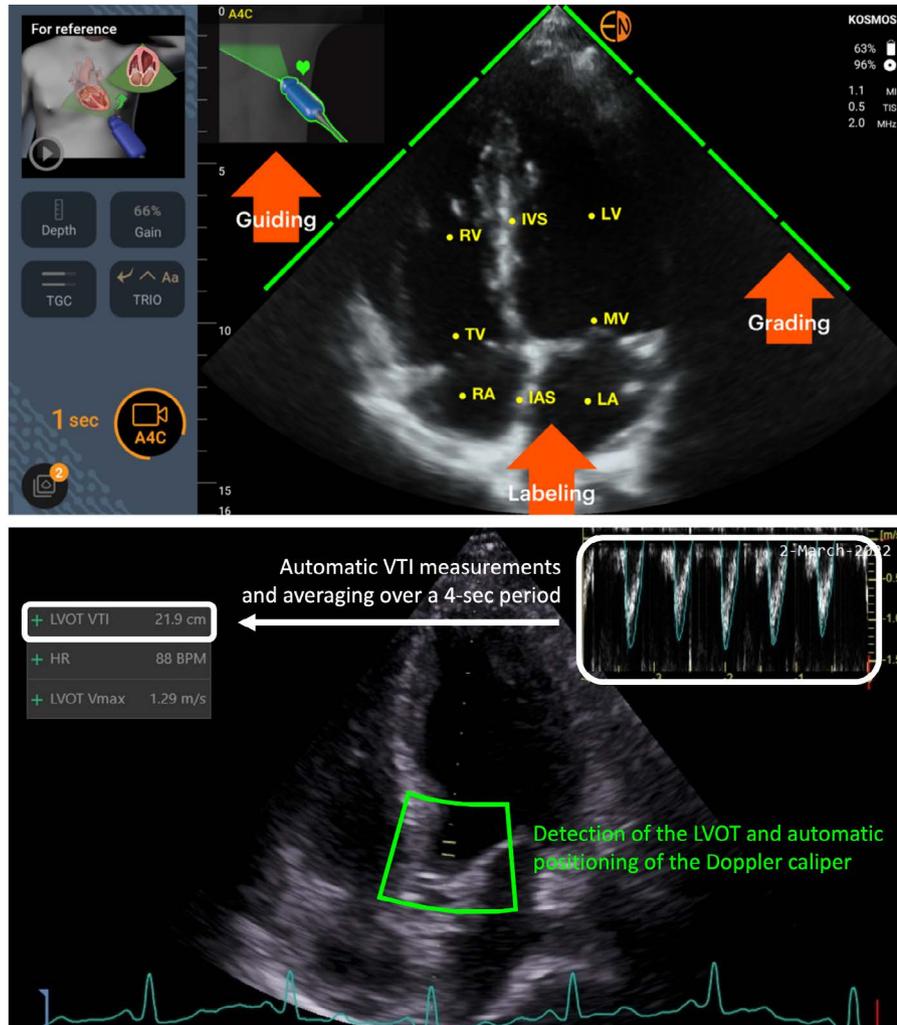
Examples of machine learning algorithms designed for point-of-care echocardiography. Top - Auto guiding to obtain an apical 4-chamber view of the heart, auto-grading to ensure optimal image quality, and auto-labelling. From EchoNous (Redmond, WA, USA), with permission. Bottom - Automatic detection of the apical 5-chamber view of the heart, automatic positioning of the Doppler caliper in the left ventricular outflow tract (LVOT) and automatic measurements of subaortic velocity-time integral (VTI). From GE Healthcare (Chicago, IL, USA) with permission.
